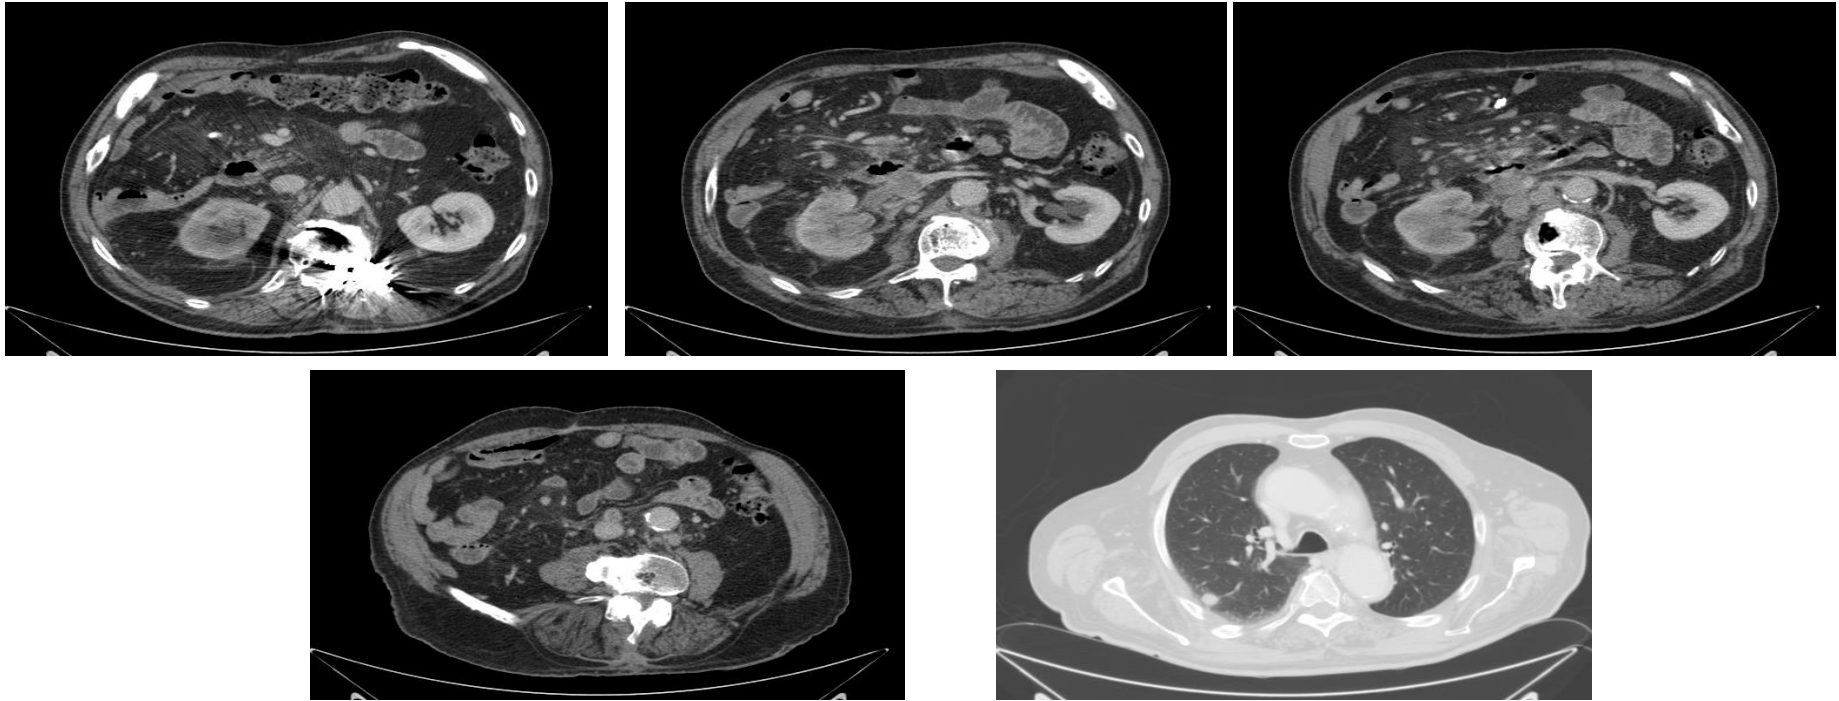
84 year old man with right colon cancer and hematuria. CT shows an infiltrative lesion in the right kidney extending into the renal hilum with affection of the excretory urinary tract and the renal vein reaching the IVC. Multiple enlarged lymph nodes and pulmonary metastases are also seen.
